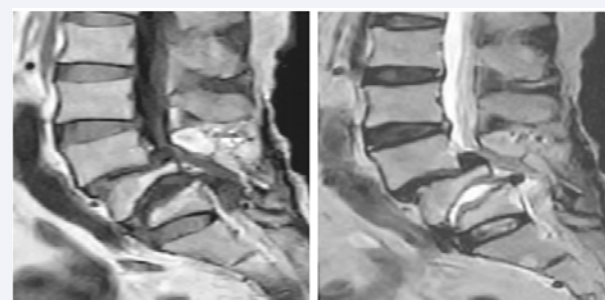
Magnetic resonance images showing L4 wedging deformity and rounding deformity of the upper endplate of L5, as well as low intensity on T1-WI and high intensity on T2-WI in L4-5 disc space, which indicate fluid collection.
